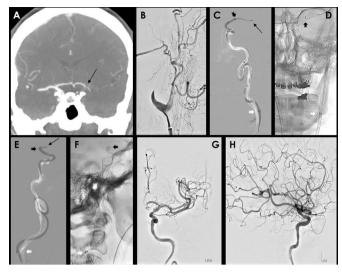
(A) Head CT angiography on coronal view demonstrating the occlusion site at the level of the left internal carotid artery (ICA) terminus (black arrow). (B) Lateral fluoroscopy image showing pseudo-occlusion of the left ICA in relation to the intracranial ICA occlusion. (C) Frontal fluoroscopic image showing severe tortuosity of the left ICA cervical segment, with tip of the Tenzing 8 delivery catheter within the clot (black arrow), the tip of the HiPoint 088 catheter within the proximal left middle cerebral artery M1 segment (black arrowhead), and Base Camp guide catheter at the origin of the cervical left ICA (white arrowhead). (D) Frontal single shot image demonstrating mild progression of the tip of the HiPoint 088 catheter (black arrowhead) after retraction of the Tenzing 8 delivery catheter. (E) and (F) Lateral fluoroscopy and single shot images in the same setting. (G) and (H) Anteroposterior and lateral fluoroscopy image showing the post single-pass recanalization of the left intracranial ICA vascular occlusion.
